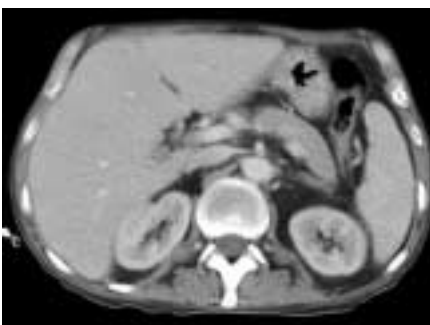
A computed tomography image of the upper abdomen, viewed as if looking from the feet towards the head. It shows the liver, pancreas, lower end of spleen, kidneys, aorta, inferior vena cava, and a vertebral body. The ribs, chest, the latissimus dorsi muscles lying behind the vertebral body can also be seen
